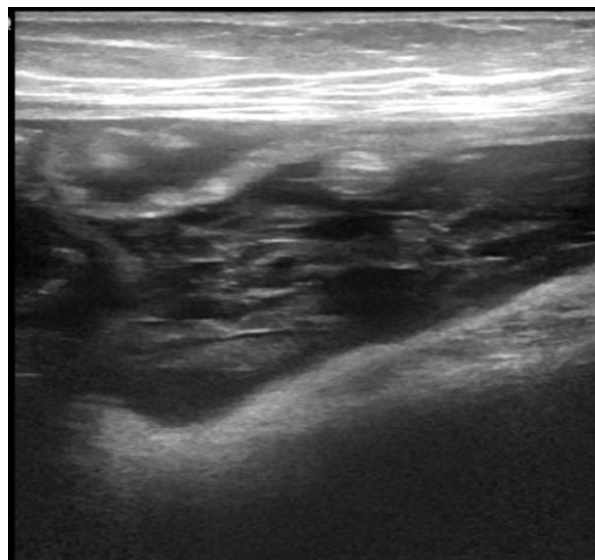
Ultrasound study showed right iliac fossa multi-septated collection which close to the dilated appendix. No significant vascularity.
